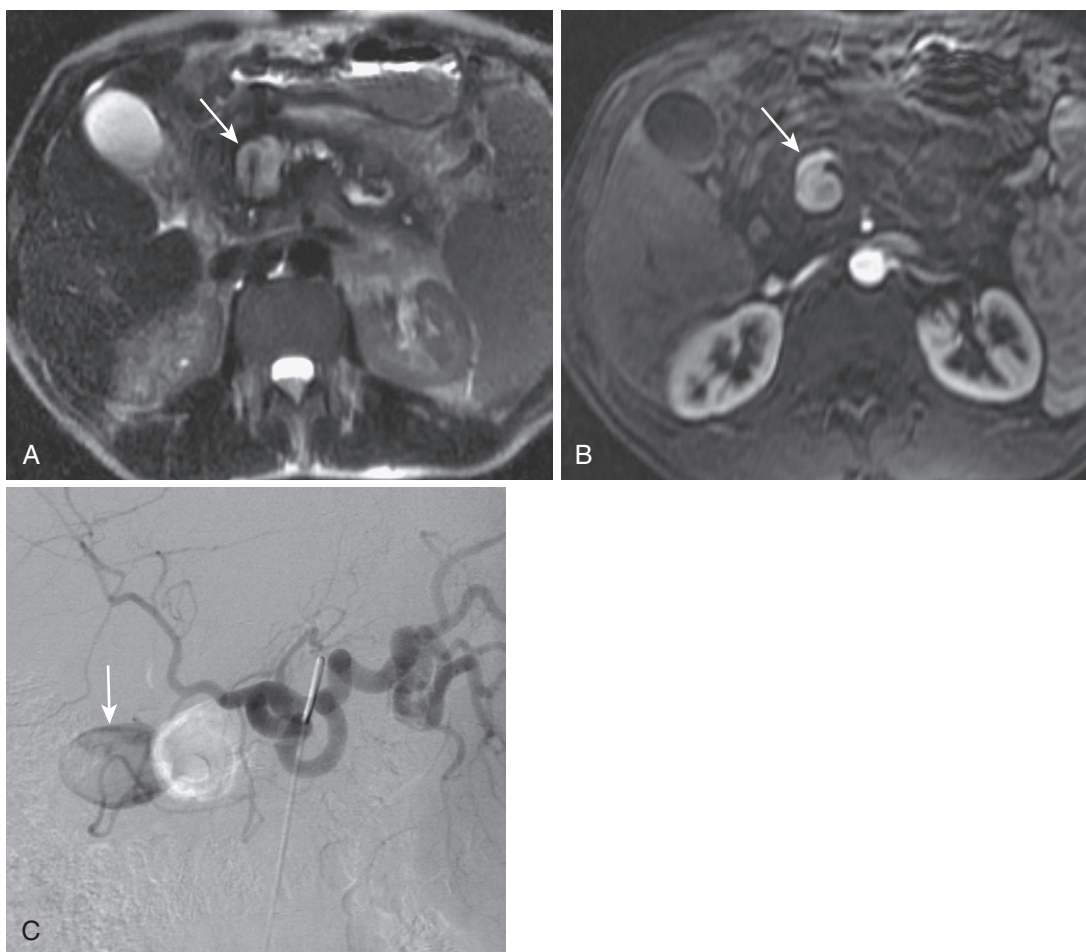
Arterial pseudoaneurysm complicating pancreatitis. A, Heavily T2-weighted image in a patient with acute or chronic pancreatitis reflected by peripancreatic inflammation and irregular ductal dilatation, respectively, shows a near–fluid-intensity lesion in the pancreatic head (*arrow*). B, Following intravenous contrast, the lesional enhancement (*arrow*) is equivalent to arterial enhancement, indicating arterial etiology and, specifically, a pseudoaneurysm arising from the gastroduodenal artery. C, The image from the celiac axis injection showed prompt enhancement (*arrow*) and confirmed direct continuity with the gastroduodenal artery.
